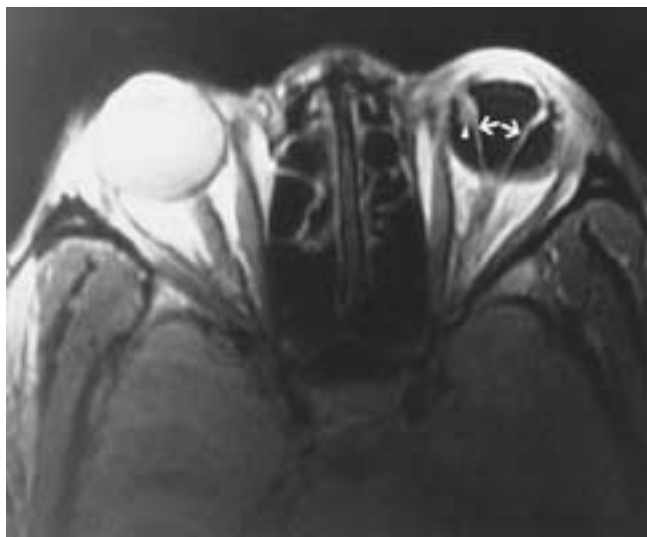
Total retinal detachment. Axial T2-weighted MR image shows a detached retina (arrows) with the characteristic V-shaped configuration with the apex at the optic disc. Hypointensity of the left globe is caused by injection of silicone oil into the vitreous, which also has escaped into the subretinal space. The arrowhead points to residual subretinal fluid not replaced by silicone oil. (From Mafee MF et al. Retinal and choroidal detachments: role of MRI and CT. *Radiol Clin North Am* 1977;25:487–507.)
